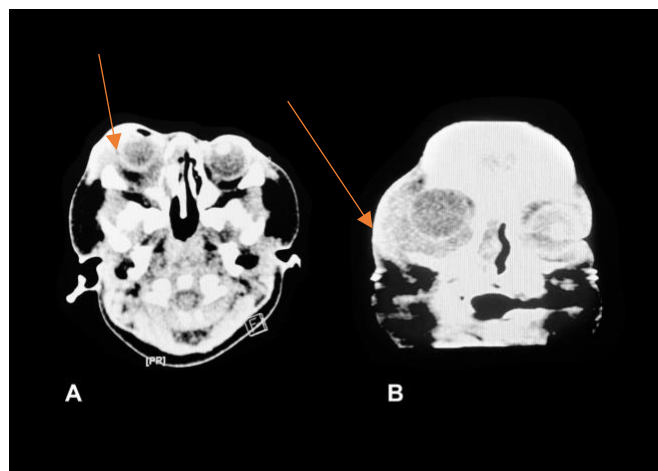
Orbital CT-scan showed (A) ethmoidal sinusitis ; (B) periorbital cellulitis with no sign of intra-cranial abnormalities
